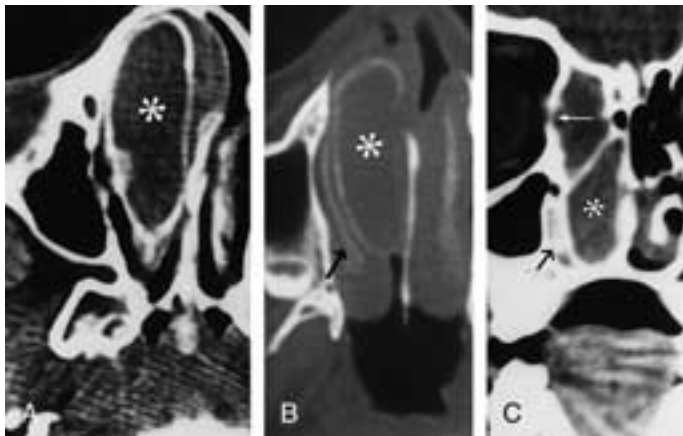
Mucocoele within a concha bullosa. Axial (A and B) and coronal (C) CT images show a prominent soft-tissue mass (*asterisk*) well circumscribed by a bony perimeter (the bony framework of the concha bullosa). The inferior turbinate is compressed against the medial wall of the maxillary sinus (*black arrow*). In the coronal image, the extent of the obstruction of the nasal cavity is apparent, as is the presence of a more superior mucocoele, which erodes the lamina papyracea (*white arrow*).
